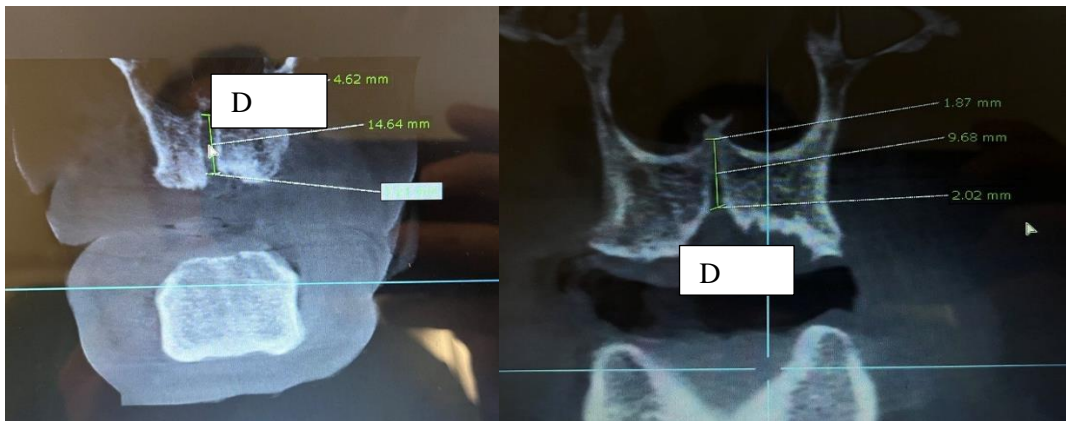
a/b: Linear analysis of Premaxilla outline in coronal view of CBCT
